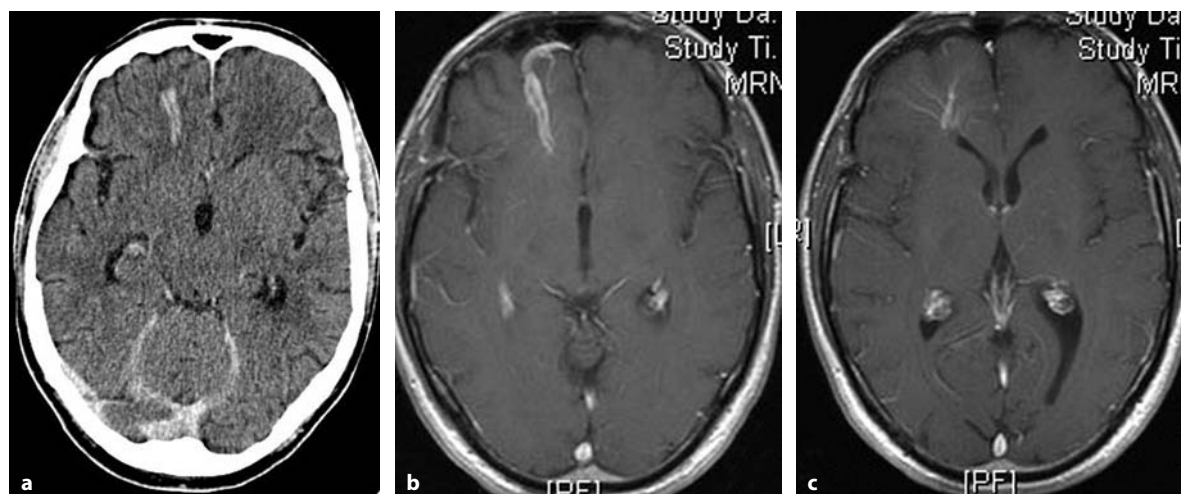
Contrast enhanced CT showed two parallel transcerebral veins, the medullary veins were not seen on 10-mm slices, T1 weighted with contrast delineate the typical structure of a DVA
